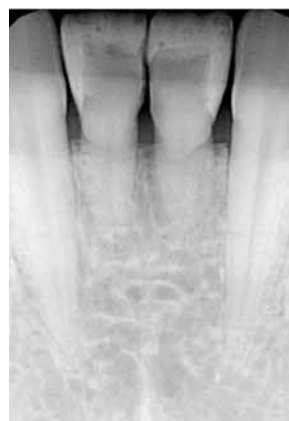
C Postoperative radiograph.
